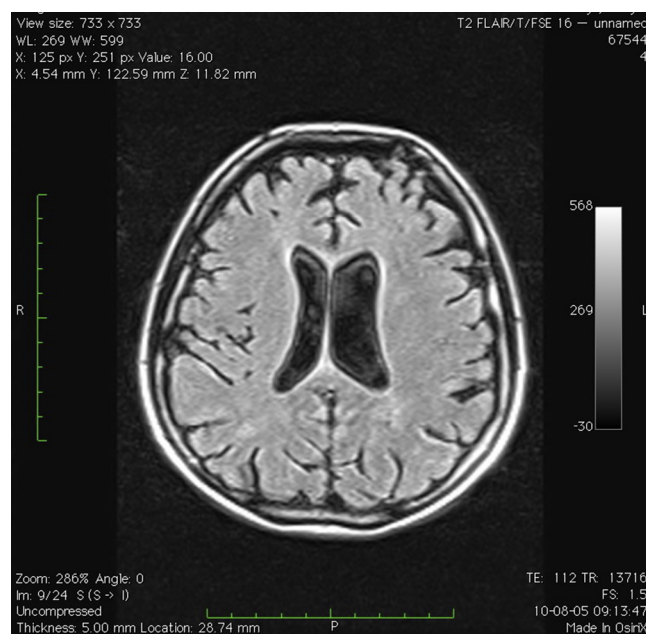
MRI of the brain (FLAIR weighted image): diffuse, hyperintensive, poorly defined lesions in semioval center, paraventricularly, at the back of the trunks of the lateral ventricles, without contrast enhancement, an atrophical enlargement of cerebral ventricles.
